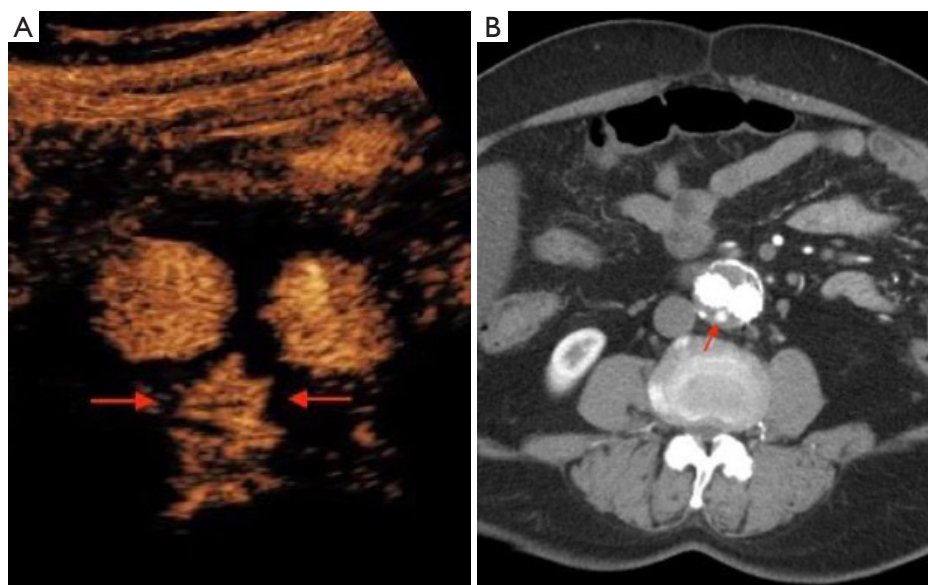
Scans of a 68-year-old female patient. A type II endoleak was found 13 months after EVAR surgery. (A) The location of the type II endoleak from the lumbar artery in CEUS (red arrows). (B) The location of the type II endoleak from the lumbar artery in CTA (red arrow). EVAR, endovascular aneurysm repair; CEUS, contrast-enhanced ultrasound; CTA, computed tomographic angiography.
